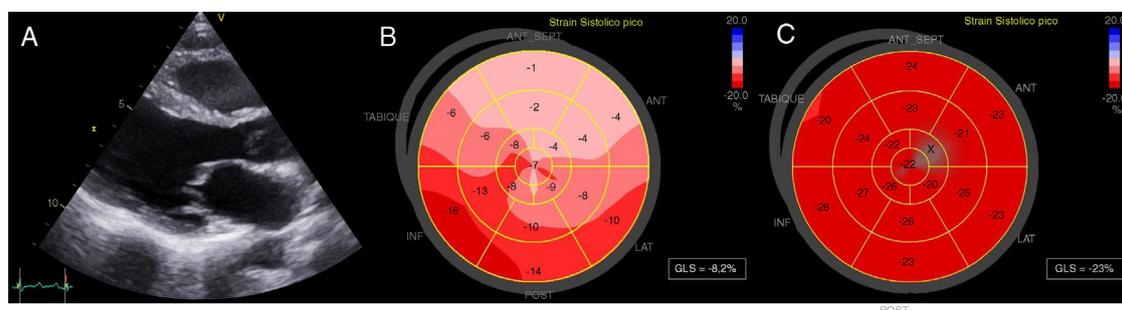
Echocardiogram: normal size of the left ventricle (A) and a greatly decreased global longitudinal strain (GLS) (B), which normalized after 6 months (C).
